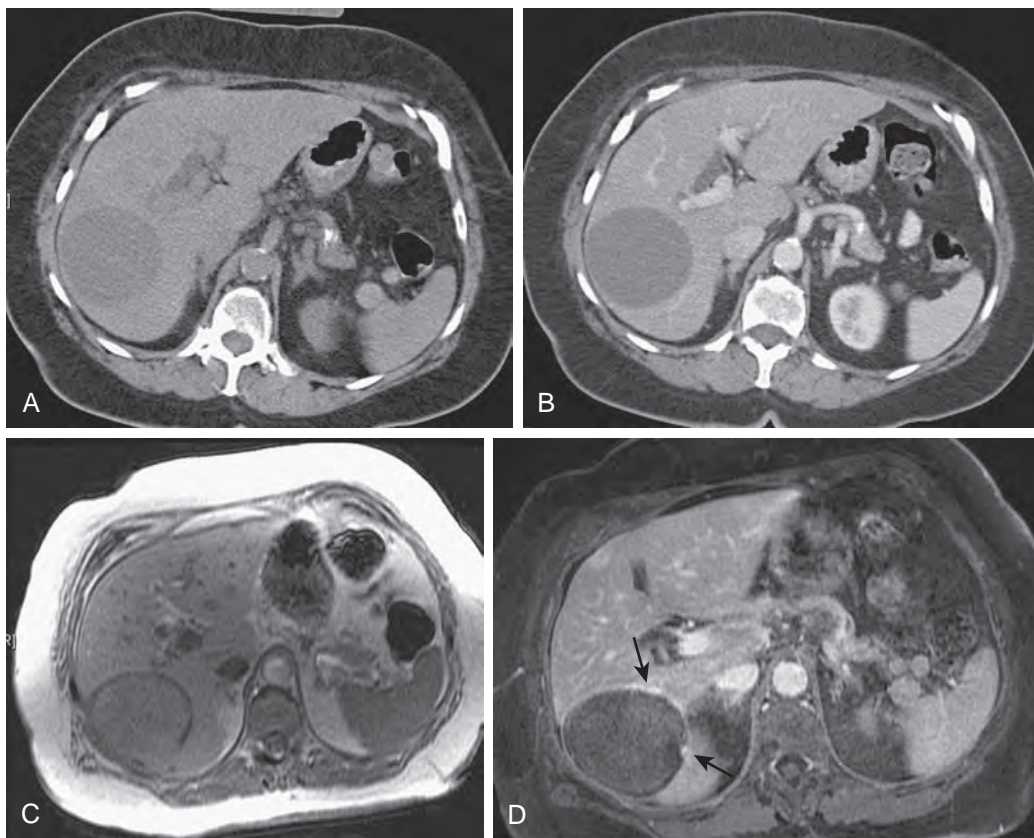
Adenoma: CT and MRI features. A. Nonenhanced CT scan shows a hypodense mass. B. On contrast-enhanced CT scan, the lesion shows no enhancement. C. On T1-weighted MR image, adenoma is slightly hypointense in comparison with the normal liver, and the fibrous capsule is isointense. D. Contrast-enhanced T1-weighted image demonstrates the subcapsular feeding vessels (arrows).
